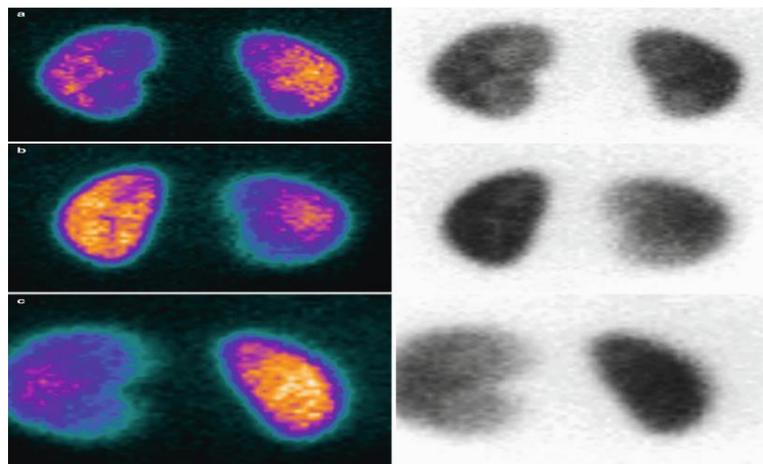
Kidney scintigraphy
